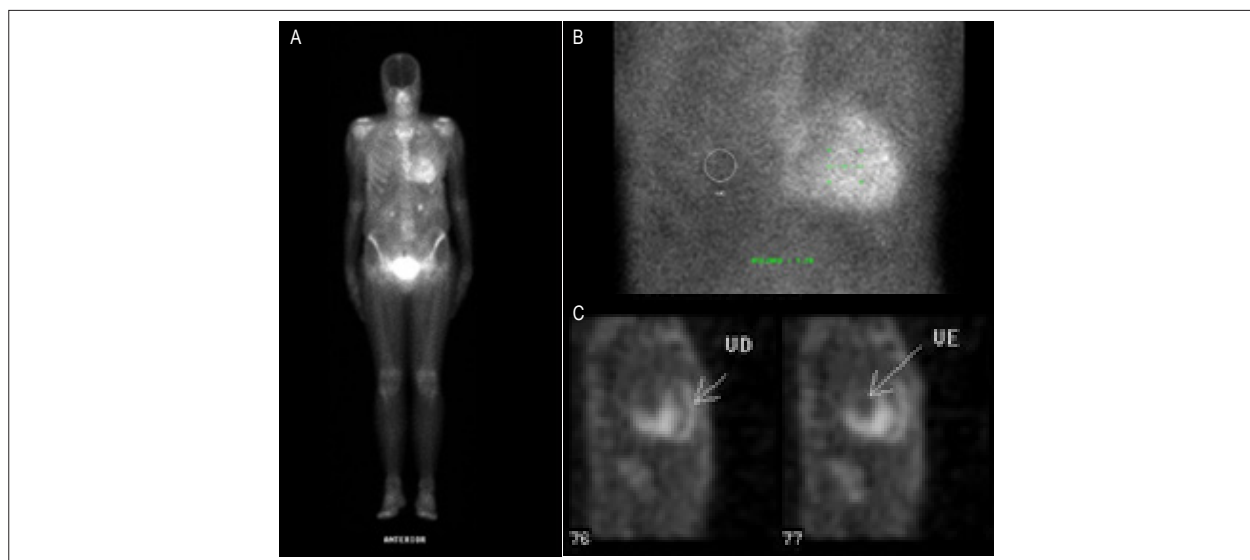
Example of scintigraphy with PYP-Tc99m to investigate cardiac amyloidosis, which was strongly positive (grade 3), suggesting the transthyretin form (ratio of pyrophosphate-Tc99m uptake degree between left and right hemithorax was equal to 1.78). (A) Full body scan with intense cardiac uptake of the radiopharmaceutical drug. (B) Regions of interest, with circles designed to measure the uptake degree. (C) Tomographic images (SPECT) detailing the marker concentration not only in the left ventricle, but also with right ventricular involvement, later confirmed by the presence of mutation in the genetic analysis. Source: author's archives.
